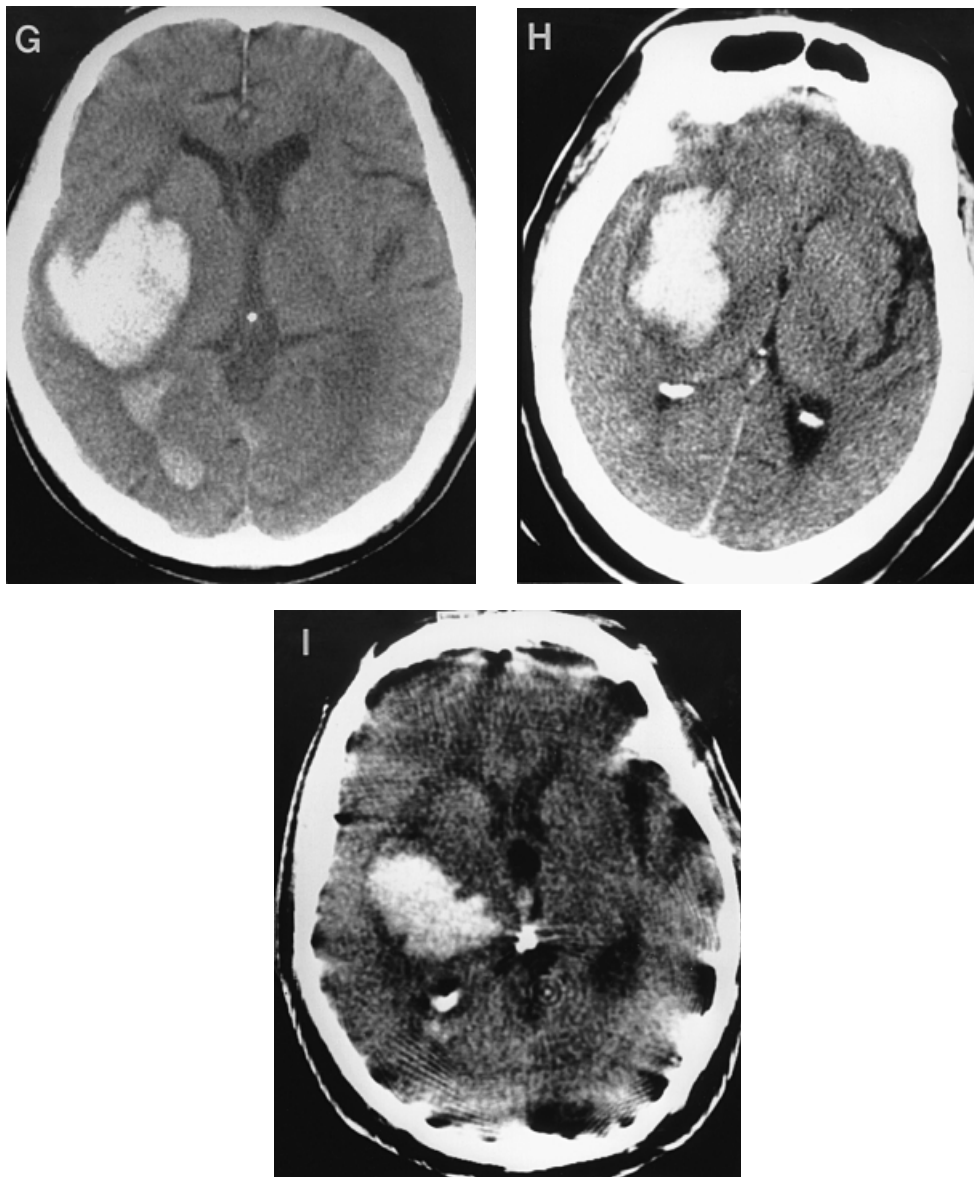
CT pictures showing the posterolateral type of SCHs. Haematomas develop in the posterior part of the putamen, often compressing or invading the posterior half of the posterior limb of the internal capsule (A–F). They occasionally extend laterally into the temporal lobe (G–I) or posteriorly rupture into the posterior horn of the lateral ventricle (G). Panels A–C are from one patient, and D–F from another, and panels G–I are from three different patients.
